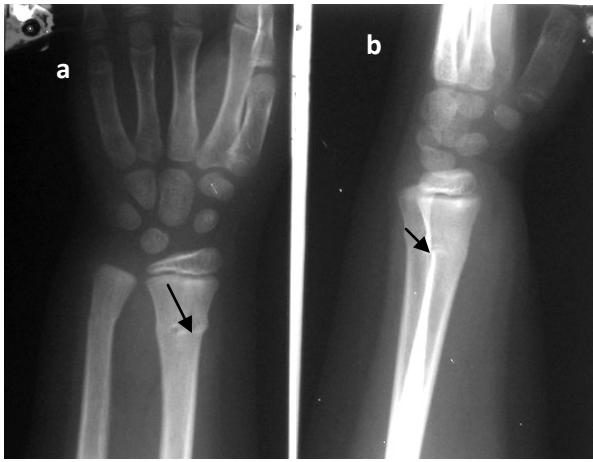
Radiograph of the radiocarpal joint in direct (a) and lateral (b) projections. Consolidation of osseal structure of radial bone metaphysis and deformation of its surface (a white arrow). Torus fracture of radial bone distal metaphysis of radius
